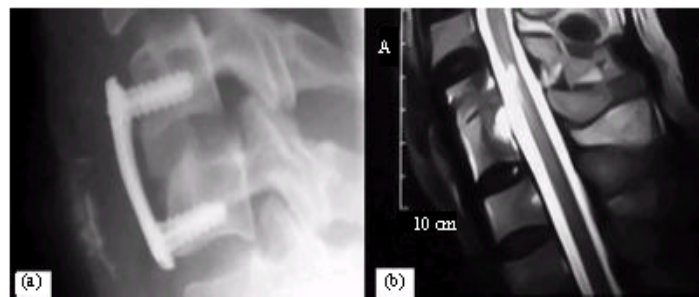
Stabilization via an anterior cervical approach with discectomy and fusion using autograft and plating. (a) Lateral cervical plain radiograph demonstrating anterior plate. (b) T2-weighted MRI shows fusion of C4-C5 and increased signal intensity of cervical cord consistent with myelopathy
